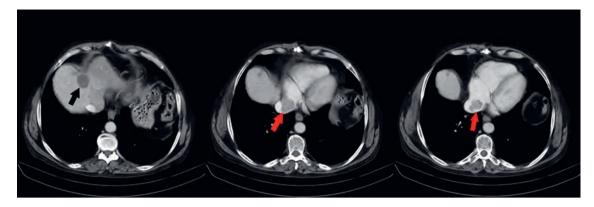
CT scan showing invasion of the inferior vena cava by the tumoral mass with extension to the right atrium (red arrows) and an extensive lesion of the liver comprehending the IV and II segments (black arrow).
